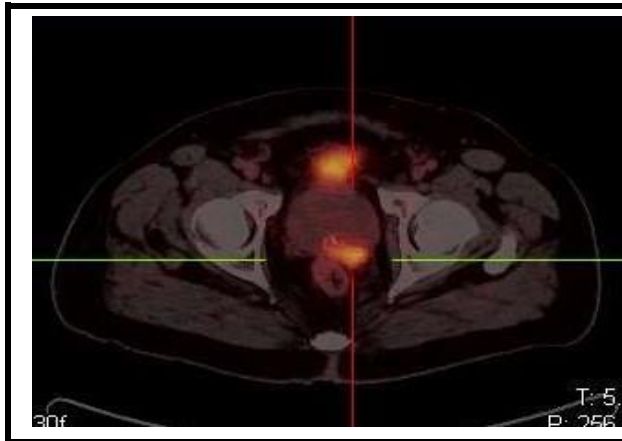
^{68}Ga -PSMA activity is noted in the left posterior-lateral aspect of the prostate gland (SUVmax=15.27).
